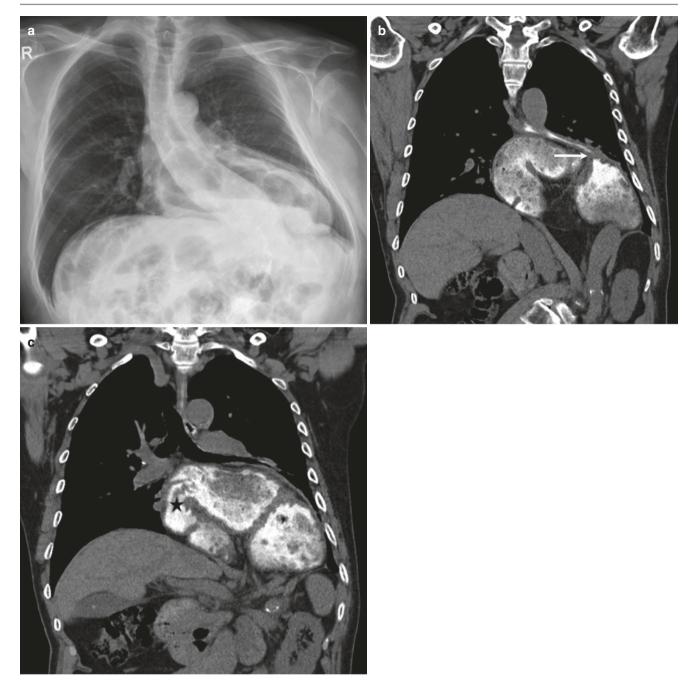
79-year-old woman with volvulus. (a) Frontal radiograph shows a large air-fluid level in the central mediastinum. (b, c) Coronal CT images with diluted oral contrast show herniation of the stomach
